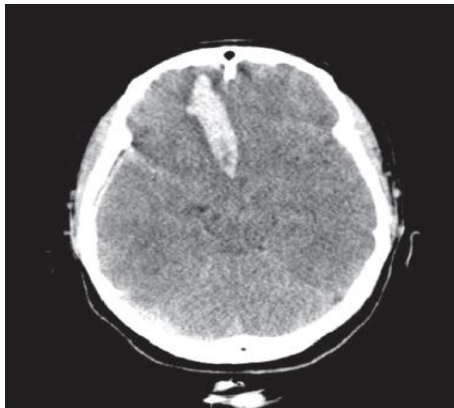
Computed tomographic scan showing a hematoma with mass effect in the right frontal base, suggesting rupture of an anterior communicating artery aneurysm.
